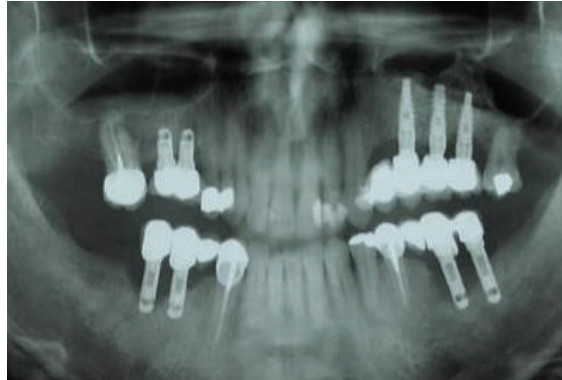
Panoramic radiograph demonstrating two inserted short implants in regions 15 and 16 with certain radiolucency around the implants and apical lesion on the mesial root of the second right molar
